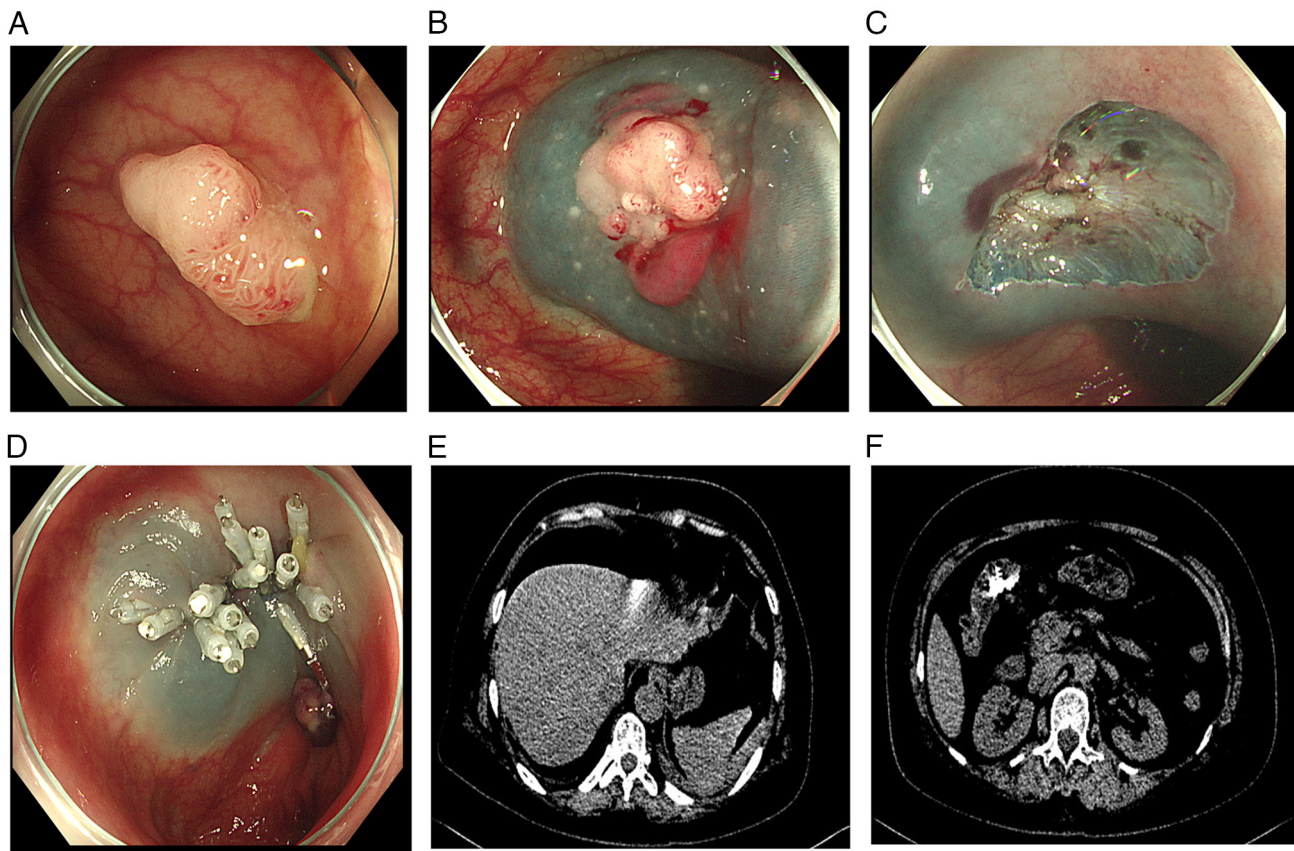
Patient 3. Images were obtained from the Gastrointestinal Endoscopy Center of The First Affiliated Hospital of Kunming Medical University (Kunming, China). Complicated perforation after endoscopic mucosal dissection. (A) A polyp located in the hepatic flexure of the transverse colon. (B) Submucosal injection. (C) Trauma after dissection and (D) closure of the trauma with titanium clips. (E) Abdominal computed tomography scan 12 h after surgery which suggested perforation and (F) a large volume of free gas was seen in the abdominal cavity and under the diaphragm.
